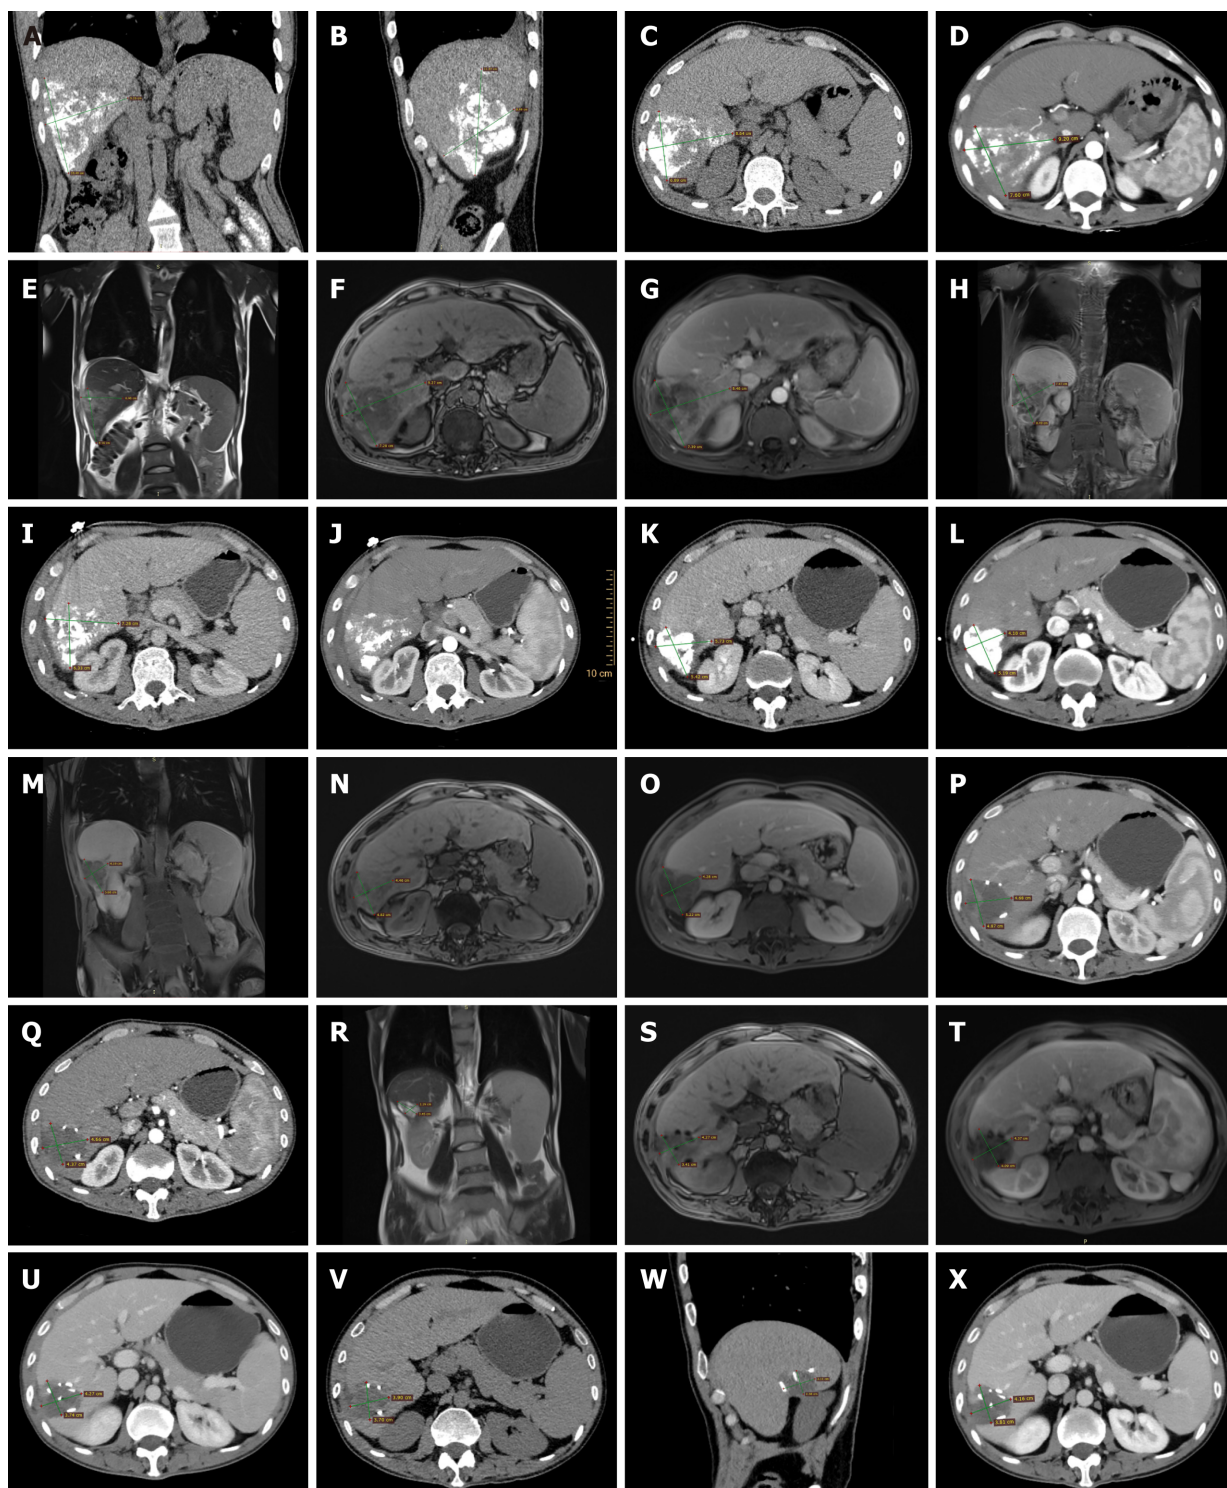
Images of patients after treatment. A-H: One month postintervention, abdominal computed tomography (CT) and magnetic resonance imaging (MRI) results showed that the liver tumor was located in segments S6-S7 (10.49 cm × 8.64 cm × 6.89 cm), with associated bleeding; I and J: Two months postsurgery, an abdominal CT revealed a decrease in the size of the tumor (7.28 cm × 6.33 cm × 4.5 cm); K-O: Three months postsurgery, plain plus contrast-enhanced abdominal CT and MRI scans indicated that the tumor size was 5.22 cm × 4.28 cm × 4.19 cm, and the activity of the tumor cells had essentially disappeared; P: Six months postsurgery, an enhanced abdominal CT indicated the presence of fluid accumulation in the right lobe of the liver in the surgical area (4.87 cm × 4.68 cm); Q: Eight months postsurgery, an enhanced abdominal CT showed a slight reduction in the size of the surgical area (4.66 cm × 4.37 cm); R-T: At nine months postsurgery, an abdominal MRI plain scan plus contrast enhancement indicated further reduction of the lesion and decreased subcapsular fluid accumulation (4.27 cm × 3.41 cm × 3.45 cm); U: Eleven months postsurgery, an enhanced abdominal CT showed no change in the lesion compared to the previous scan (4.27 cm × 3.74 cm); V-X: Fifteen months postsurgery, an abdominal plain plus contrast-enhanced CT scan indicated no change in the lesion compared to the previous scan (4.16 cm × 3.81 cm × 3.11 cm).
